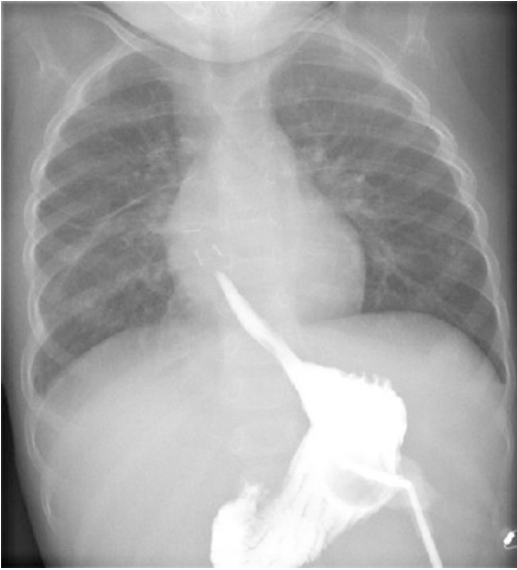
Radiographic investigation of the lower oesophageal remnant in a 1-year-old child with LGEA. He had treated by traction sutures (the metal clips are marking the extraluminal end of the pouch). Contrast medium has been installed via the gastrostomy into the stomach and is delineating the length and the lumen of the lower pouch
